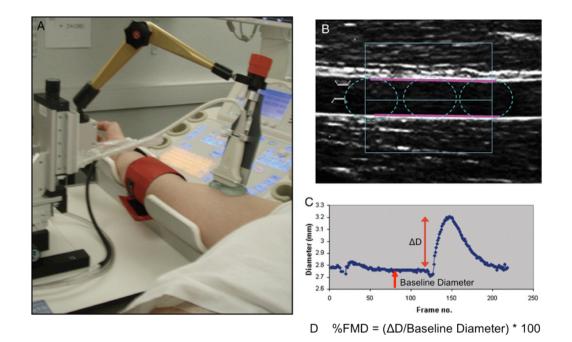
Flow-mediated dilatation (FMD). Depicted is the experimental set-up for a brachial FMD measurement including the recommended positioning of the sphygmomanometer cuff and the use of an ultrasound probe holder (A). A B-mode ultrasound image of the far and near wall of the brachial artery is depicted with additional placement of the region of interest box using an edge detection analysis software for flow-mediated dilatation analysis (B). The consecutive measurement of the brachial artery diameter, as generated by edge detection software, allows assessment of the vasodilatory response (C). From the difference between maximum and baseline diameters (Δ D) %FMD can be calculated (D). The figure was adapted from Charakida et al. [146].
